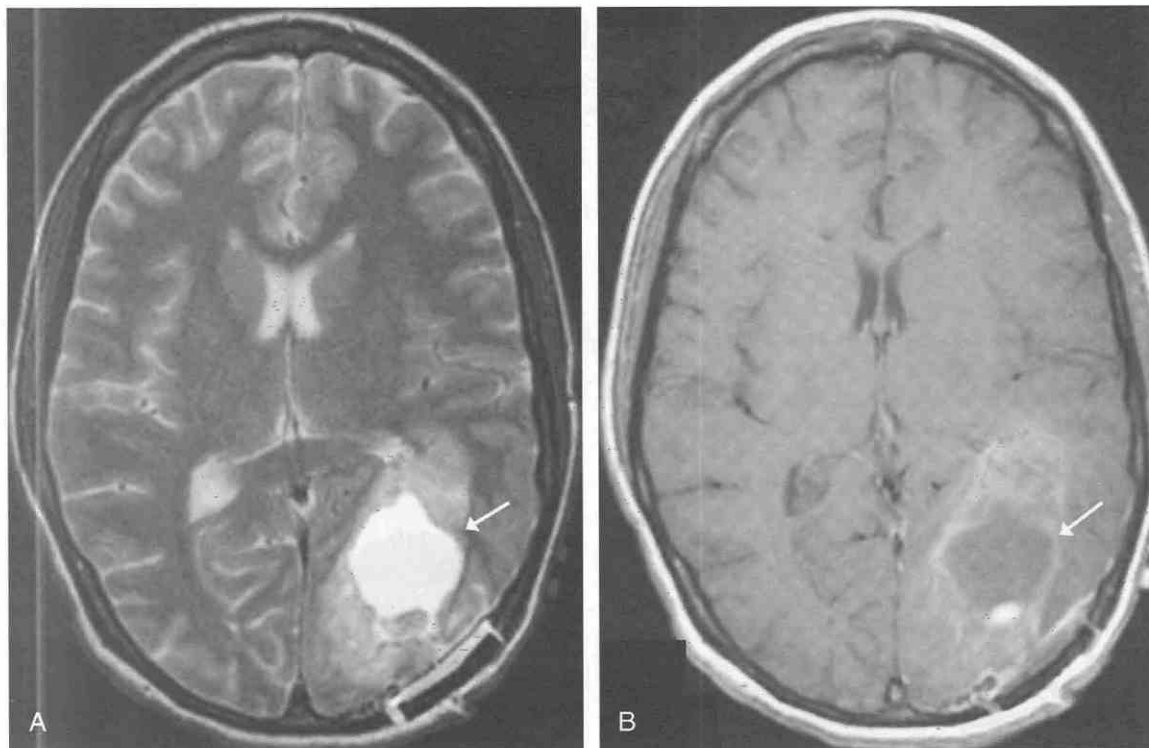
Primitive neuroectodermal tumor in the left parietooccipital region (postcraniotomy). *A*, Axial T2-weighted MR image demonstrates an ovoid heterogeneously hyperintense mass in the left parietooccipital white matter with extension into the overlying convexity cortex and a single large intratumoral sharply margined central collection of marked hyperintensity, likely representing a combination of necrosis, surgical resection cavity, and/or cyst formation (arrow). The mass compresses and displaces the atrium of the left lateral ventricle from behind. *B*, Following intravenous gadolinium, an axial T1-weighted image demonstrates irregular contrast enhancement within the tumor interstices without enhancement of the central cavity (arrow).
